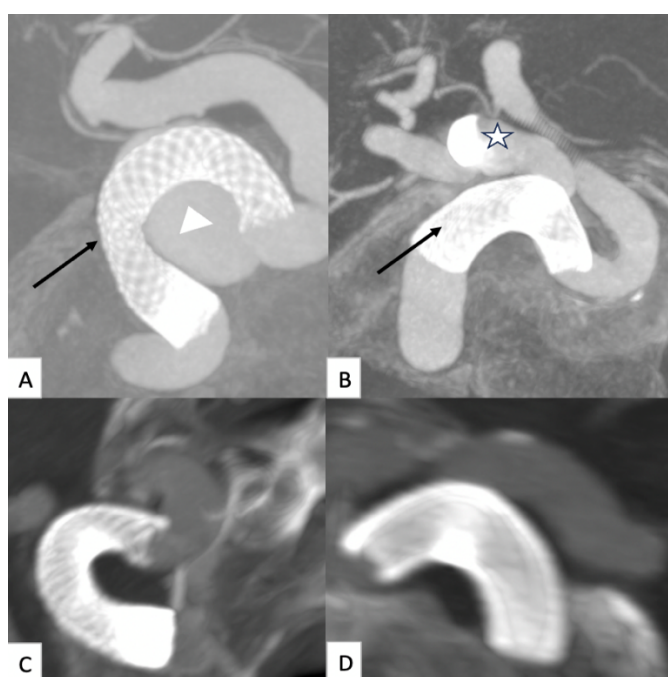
Postoperative (A-B) and first-year (C-D) control CT angiography images of the patient. No residual aneurysm was seen in the control first year cranial CT angiography images. Black arrow: flow diverter stent, arrowhead: right ICA cavernous segment aneurysm, asterisk: PPTA aneurysm
